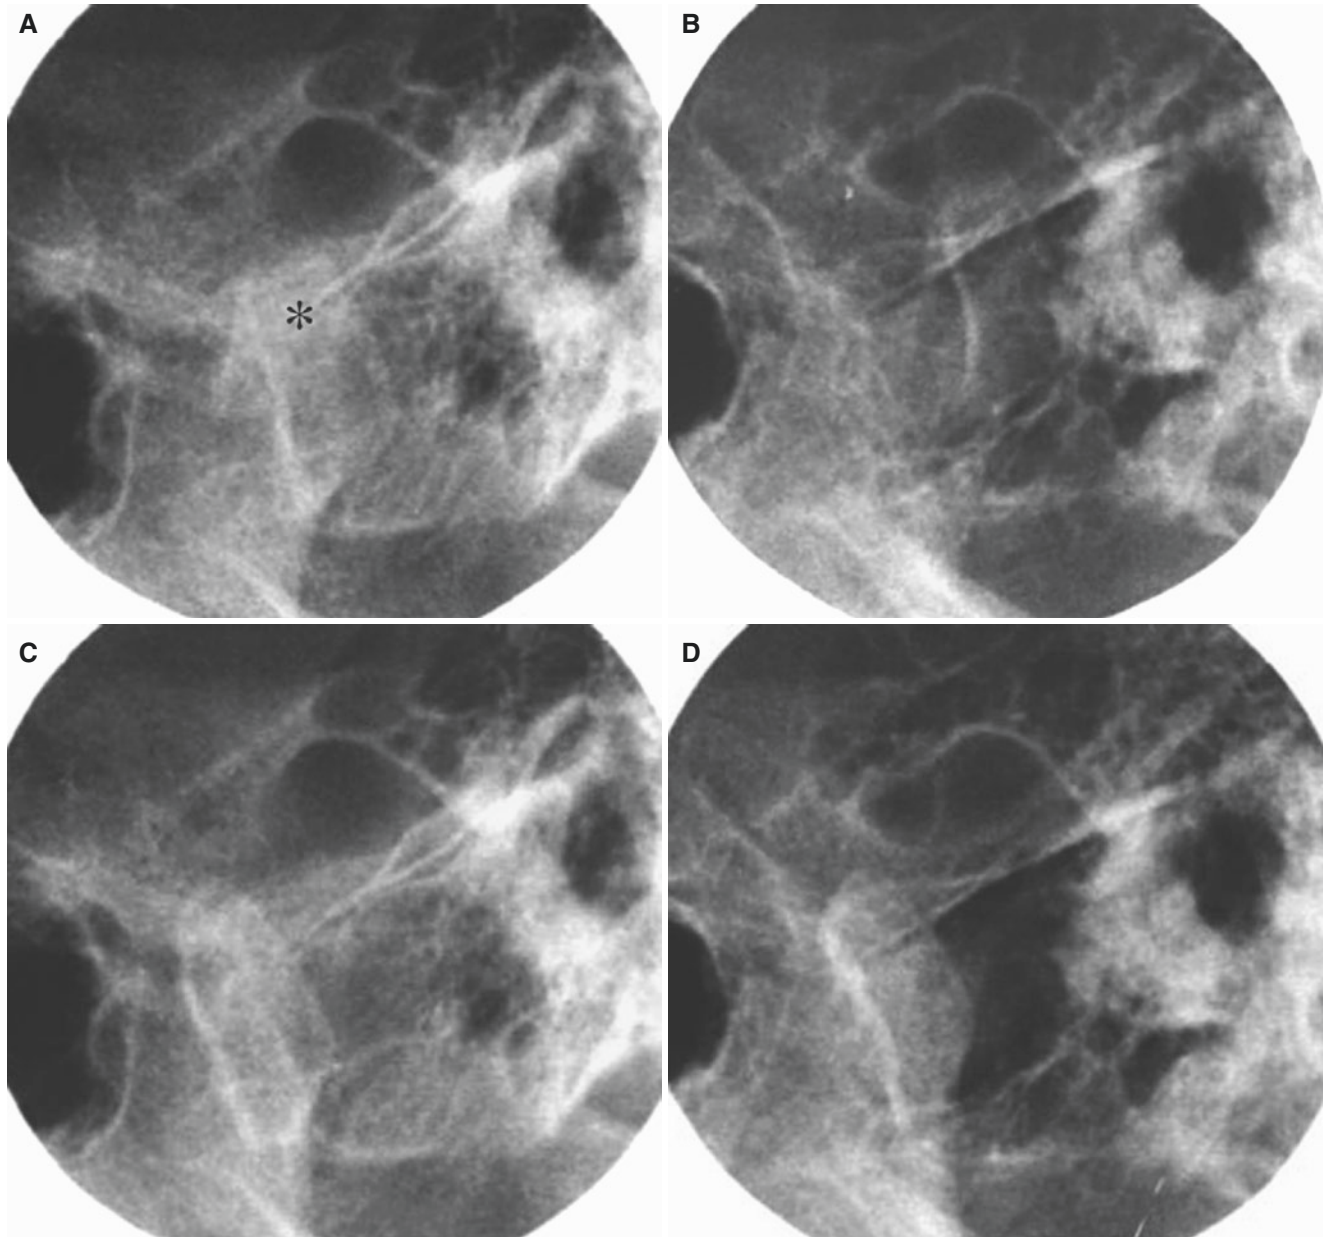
Non-fracture trauma to the mandible; 14-year-old male with trauma to the chin due to bicycle accident and problems with mouth opening and dental occlusion. (A, B) Conventional (lateral transcranial) TMJ radiography at closed mouth shows abnormal position of condyle
